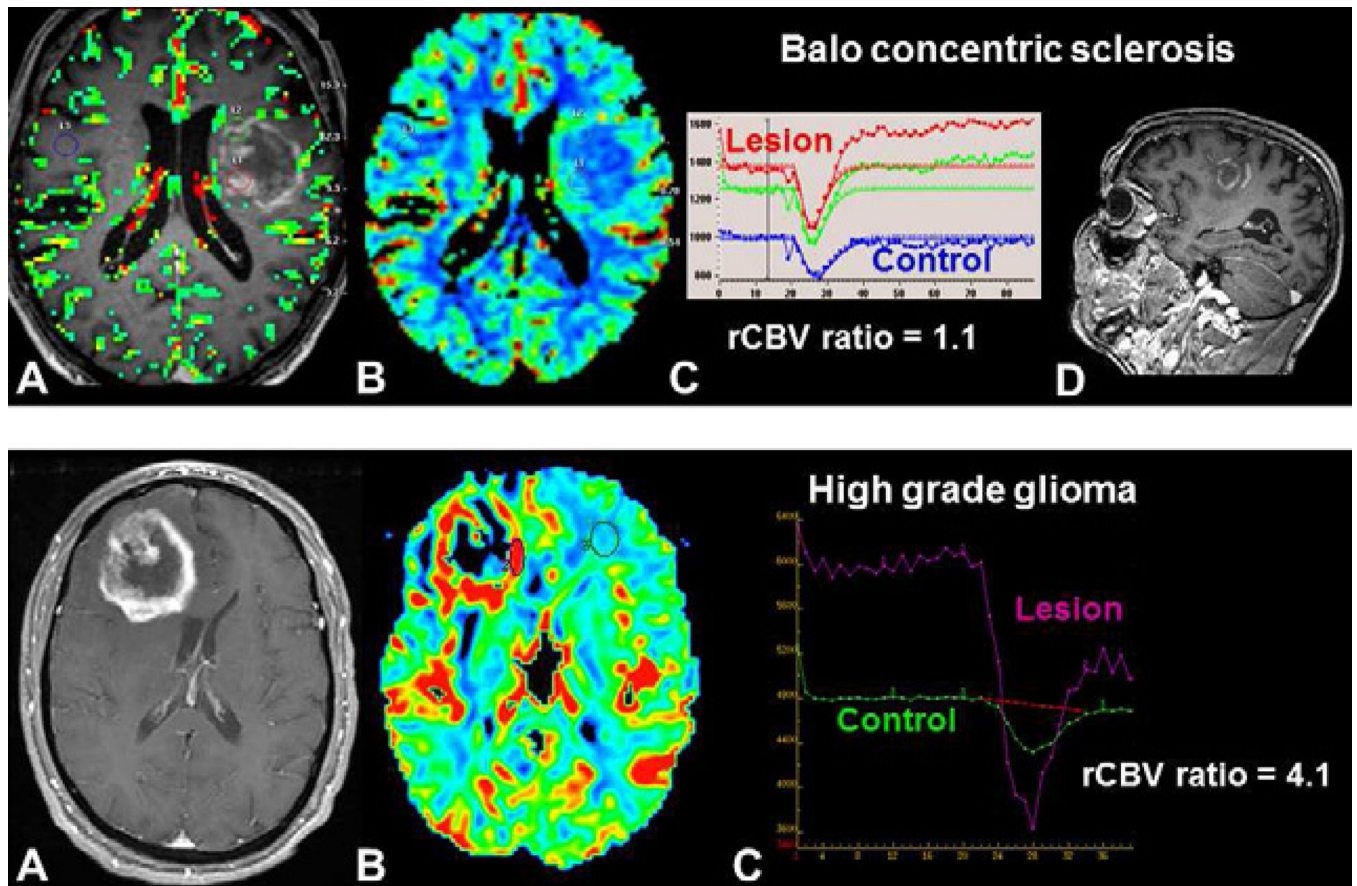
Differential diagnosis of an intracranial mass using DSC-MRI. Both patients presented with a peripherally enhancing, centrally necrotic mass (A, E). In Balo concentric sclerosis (upper row), DSC-MRI demonstrates a low rCBV ratio (C) without visible increased perfusion on the rCBV color map (B). Concentric enhancement of the lesion is seen on sagittal post-contrast T1-weighted image (D). In a high-grade glioma (lower row), DSC-MRI demonstrates increased perfusion within the enhancing portions of the lesion (F) with a high rCBV ratio (G).
